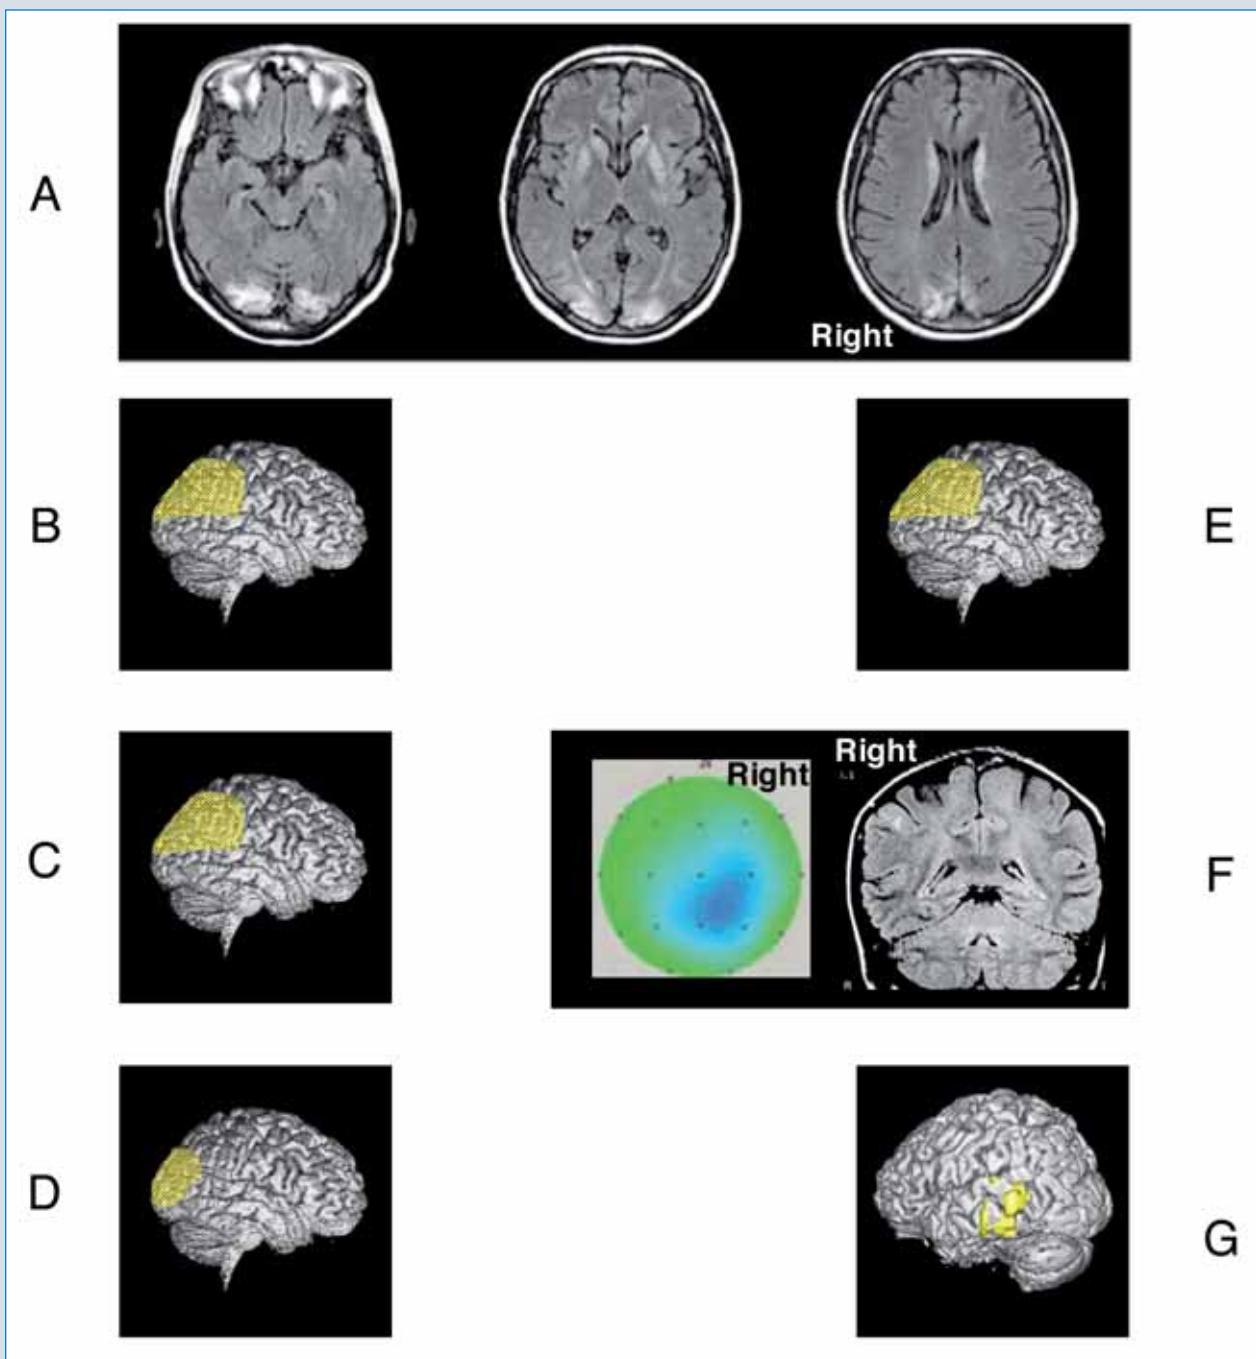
Lesion location in 7 previous cases with autoscopic hallucinations. Figure 3A shows a MRI-defined bi-occipital lesion extending to the right parieto-occipital cortex as reported by Zamboni et al. [24], reproduced with permission. Lesion location (indicated in yellow) of patients described by Maillard et al. [26] (case 2, Figure 3B), Maillard et al. [26] (case 3, Figure 3C), Bhaskaran et al. [27] (Figure 3D), and Kölmel et al. [10] (Figure 3E) is estimated on a lateral cortical view for all patients. Note the predominance of parieto-occipital and occipital lesions. The MRI-defined right temporo-parieto-occipital lesion reported by Maillard et al. [26] (case 1, Figure 3F) is shown with topographic distribution of interictal epileptic activity over the right parieto-occipital region. Figure 3G shows lesion location of the patient reported by Blanke et al. [1] (case 6) in temporo-occipital cortex.
